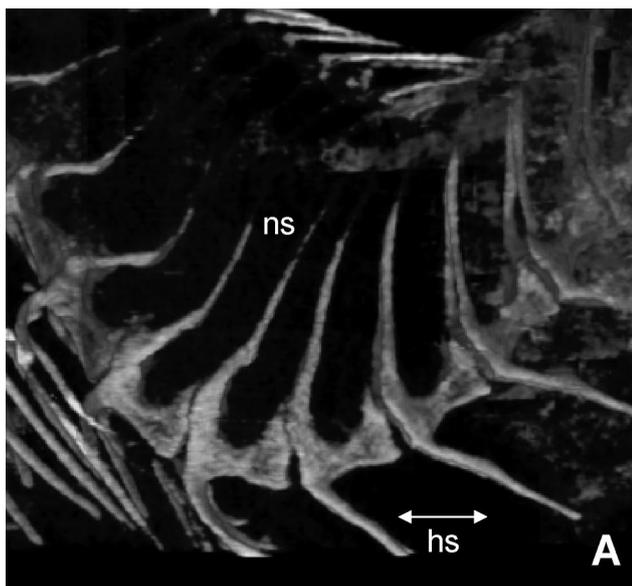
Vertebral detail shows no fusion or breaks. CT of apical vertebrae for curved (A) and normal (B) guppy. Scan consists of 350 0.4-mm slices. Both guppies are of the *curveback* lineage. *hs*, indicates hemal spines; *ns*, neural spines.
